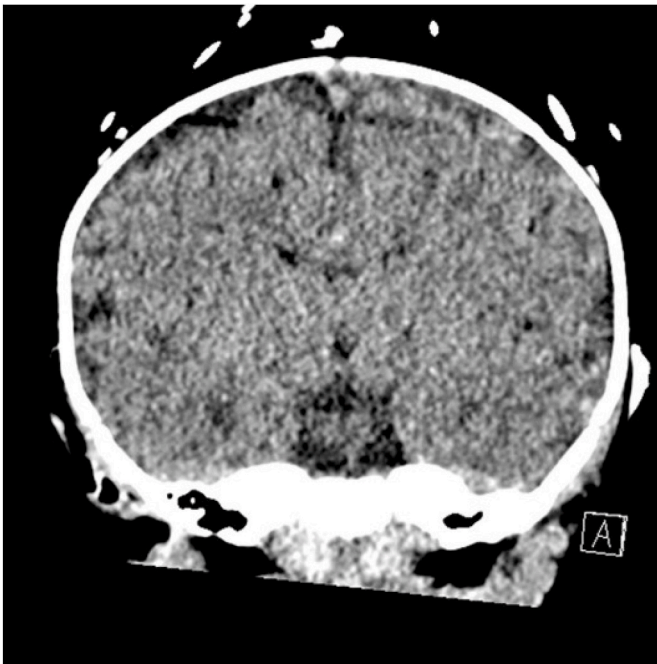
Coronal view of head CT after 38 hours of normal neurologic status followed by more severe neurologic decompensation.
